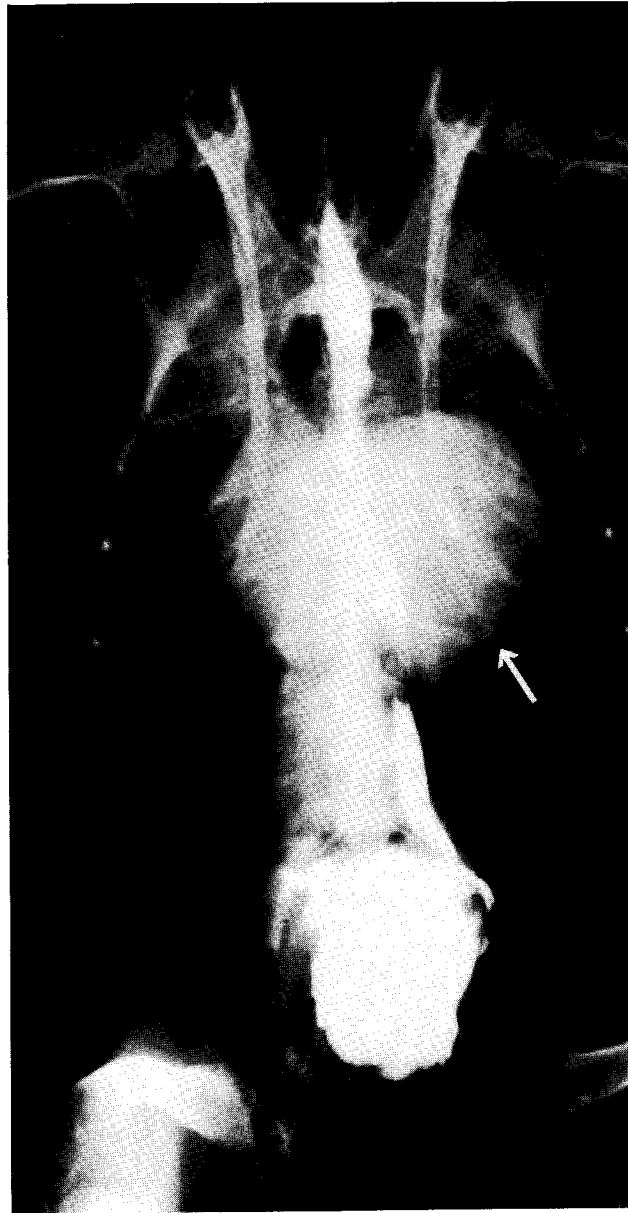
Ventrodorsal radiograph, showing left atrial enlargement (arrow). Barium sulfate cream was administered orally.
